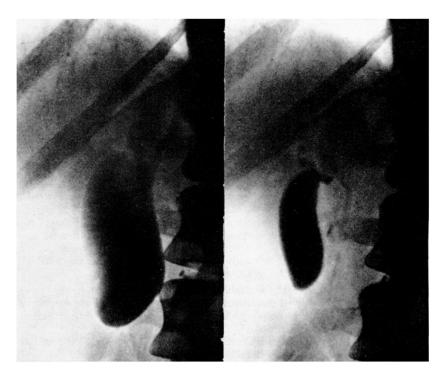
Contraction of the gall bladder of a volunteer elicited by $10\,\mu\text{g/kg}$ of the heptapeptide administered by nasal insufflation. On the left basal roentgenogram; on the right 30 min after the administration of the peptide.
